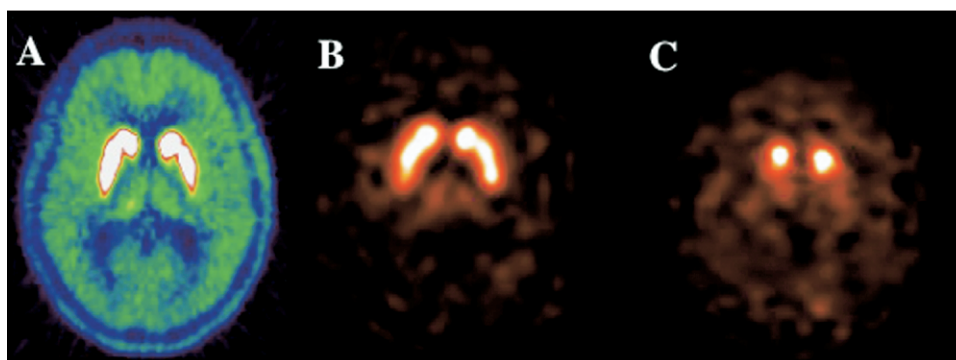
Presynaptic dopamine neuron imaging with ^{18}F -DOPA (A, healthy control) and the dopamine transporter agent ^{123}I β -CIT (B, healthy control; C, Parkinson's patient). Despite different molecular targets, the presynaptic PET and SPECT agents demonstrate similar patterns of uptake in healthy and diseased states and are all useful for the visual evaluation of the integrity of the dopaminergic projections to striatum.
